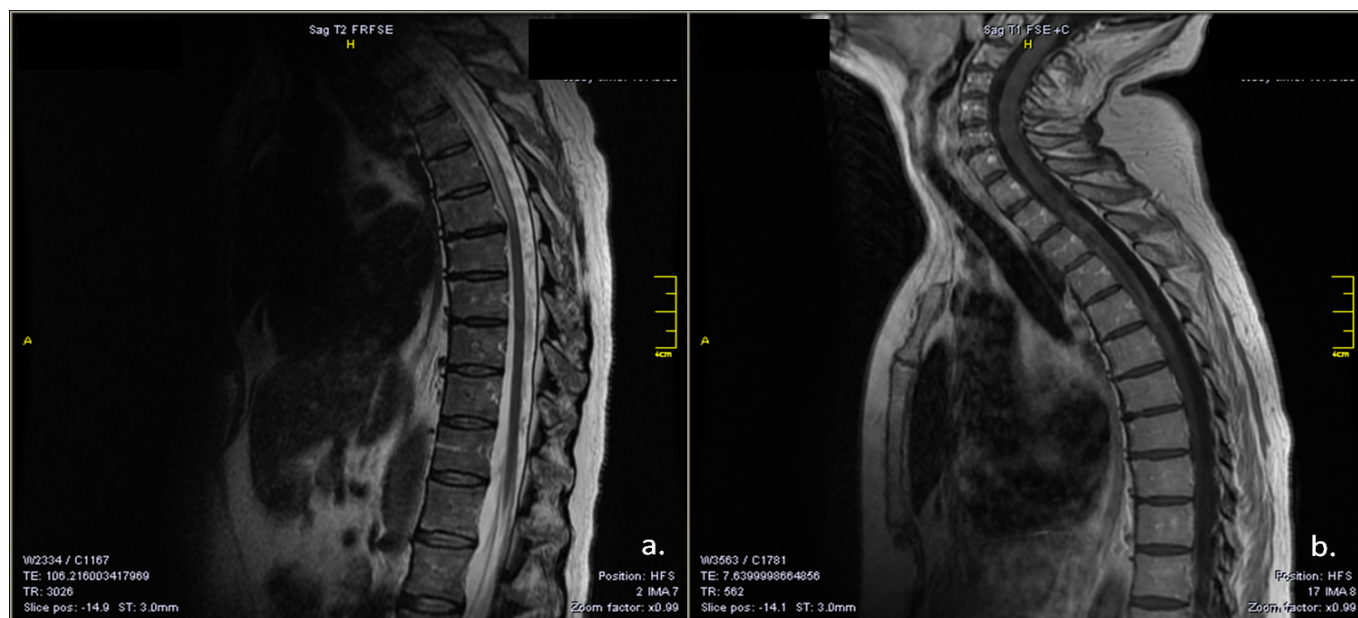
Spinal cord MRI a. Sagittal T2 sequences showing a hyperintense intramedullary lesion extending from D2 to D7 level; b. Post contrast sagittal T1 sequences showing mild peripheral gadolinium enhancement
